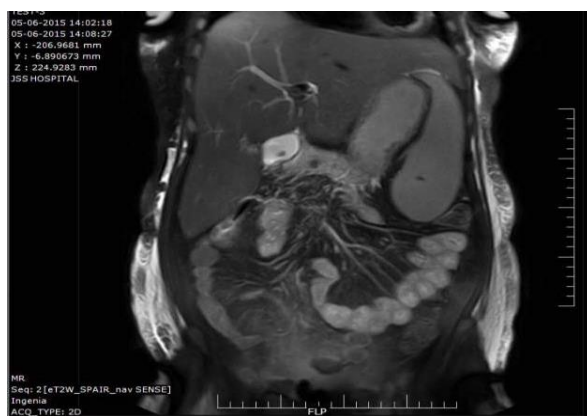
MRI of the abdomen and left breast
